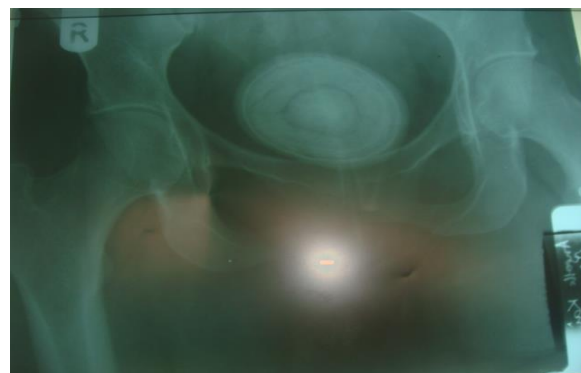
Pelvic X-ray Result
